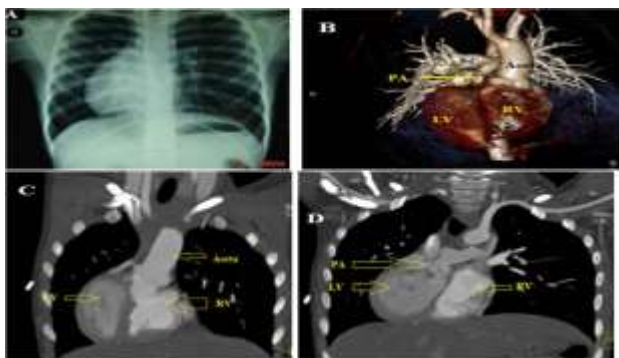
(A) Chest X- ray AP view showing Dextrocardia, (B, C, D) Cardiac CT showing cc-TGA, with Dextrocardia
